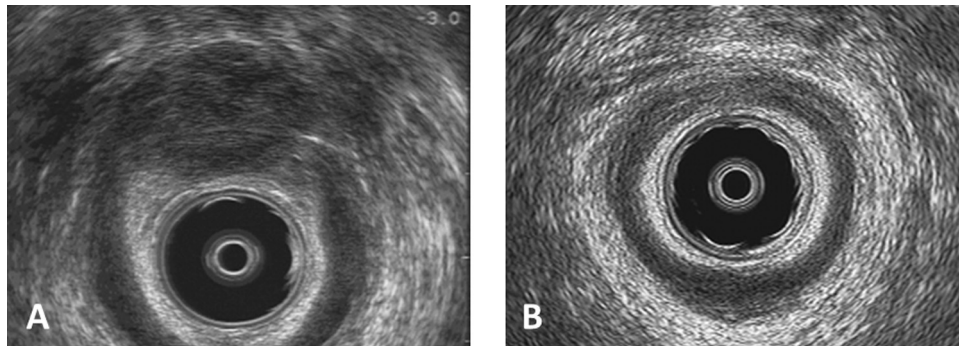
Preoperative 360° transanal ultrasound (A). Postoperative 360° transanal ultrasound (B).
